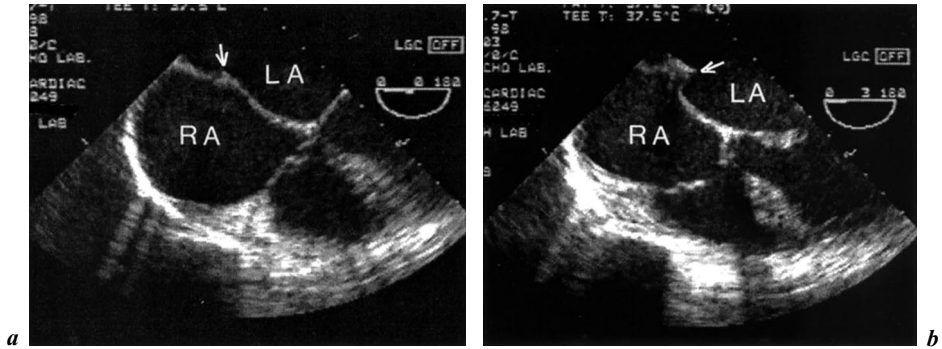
Transesophageal echocardiogram during transseptal puncture. a Tenting of the interatrial septum (arrow) produced by the tip of transseptal wire. b Tip of the catheter penetrating the interatrial septum (arrow). LA = Left atrium; RA = right atrium.
